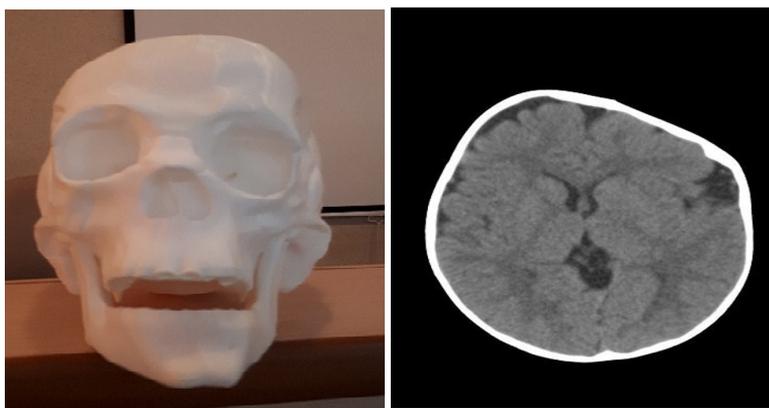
CT scan and 3D model of orbital anomaly, plagiocephaly
